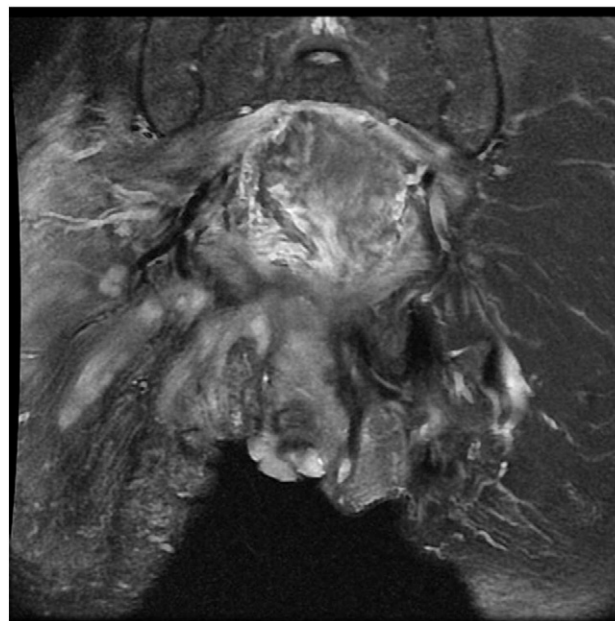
MRI of the pelvis T2 showing advanced locoregional disease.
